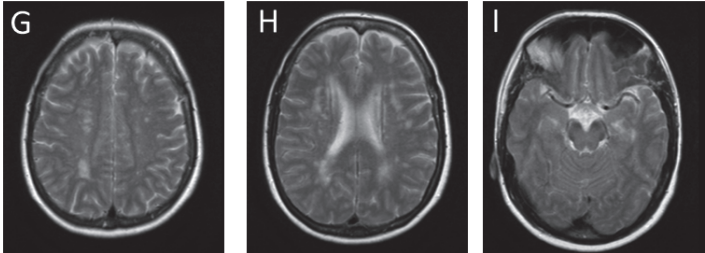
Brain MRI of elderly asymptomatic and paucisymptomatic individuals with a *NOTCH3* mutation compared to MRI in classical CADASIL. (A-C) Brain MRI images of a classical CADASIL phenotype in the 6th decade. (A-B) FLAIR images showing extensive confluent symmetric white matter hyperintensities and multiple lacunar infarcts (arrows indicate random samples). (C) T2*-weighted MRI showing multiple microbleeds (open arrows indicate random samples). (D-F) Brain MRI images of a female, diagnosed with CADASIL after predictive DNA testing at 78 years of age, with only very mild clinical symptoms. (D, E) FLAIR images showing symmetric white matter hyperintensities, but no lacunar infarcts. (F) T2-weighted MRI showing some small microbleeds (open arrows). (G-I) Dual echo images of a female who was still clinically asymptomatic at 73 years of age. MRI images were made at 58 years of age, showing very mild symmetric white matter hyperintensities, no lacunar infarcts and no microbleeds.
